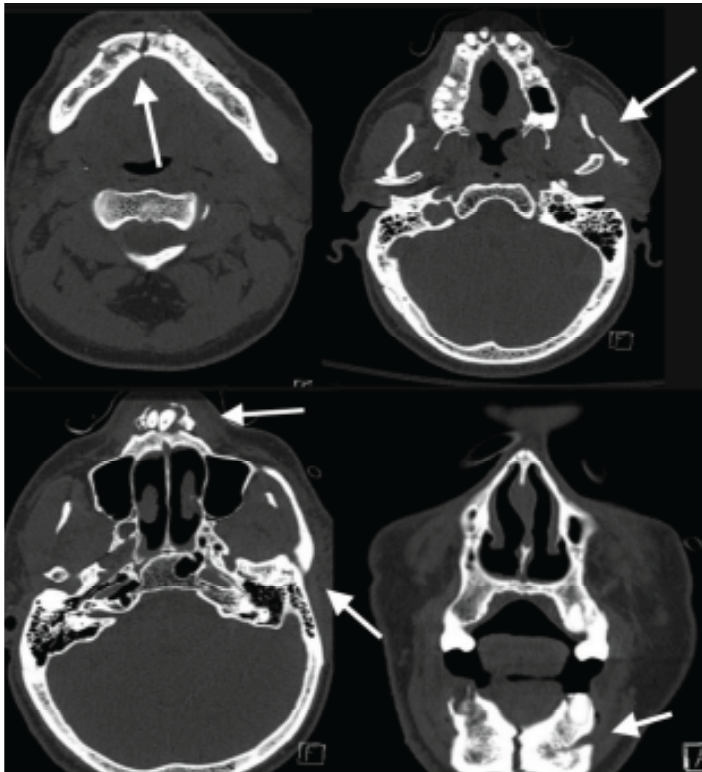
Maxillofacial computed tomography images of the patient's multiple facial fractures, including a comminuted symphysis fracture, subcondylar fracture, and teeth intrusions (arrows)
